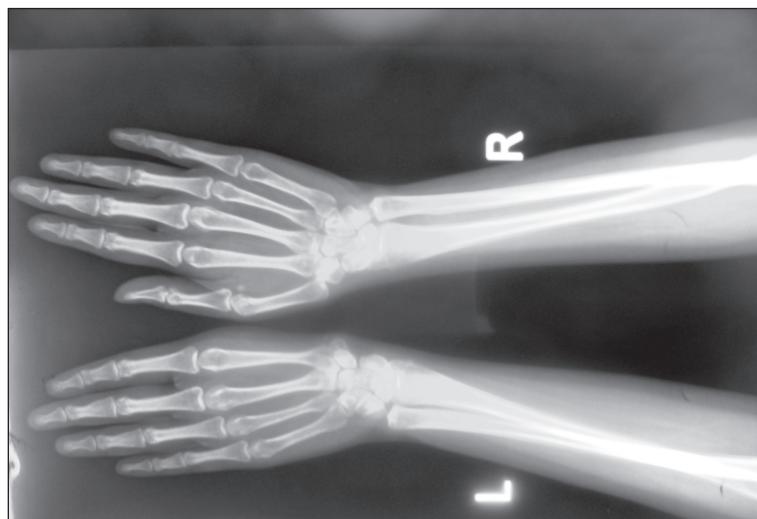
Plain radiograph of the hands.
